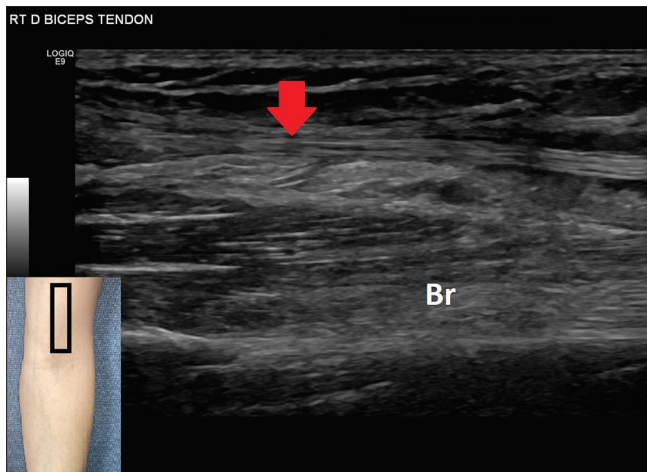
Longitudinal ultrasound image of the intact long head component of the bifid distal biceps tendon (red arrow) demonstrating a normal thin uniform linear hyperechoic tendon. Br: Brachialis muscle
